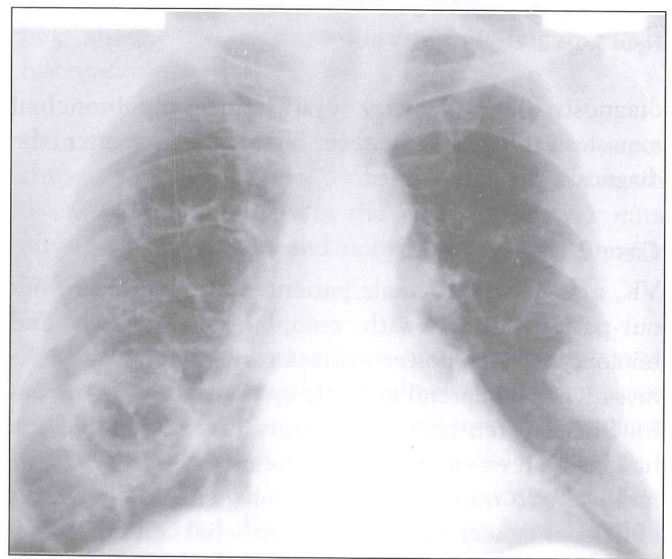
Postero-anterior chest X-ray (2001)
